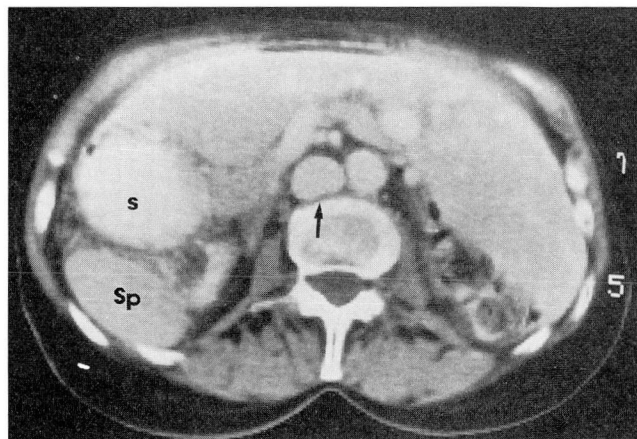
Contrast-enhanced abdominal CT scan revealing midline liver, spleen (Sp), and stomach (S) on the right; normal aorta; prominent azygous vein (arrow); and absence of the normal inferior vena cava.
